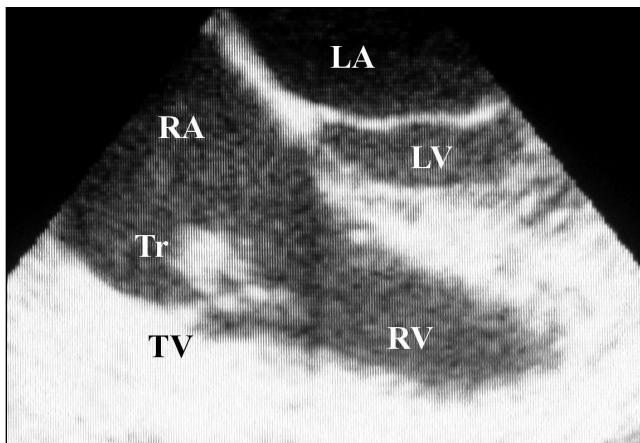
Transesophageal echocardiographic image displaying a sessile echogenic mass (thrombus [Tr]) attached to the atrial side of the tricuspid valve (TV). LA Left atrium; LV Left ventricle; RA Right atrium; RV Right ventricle
